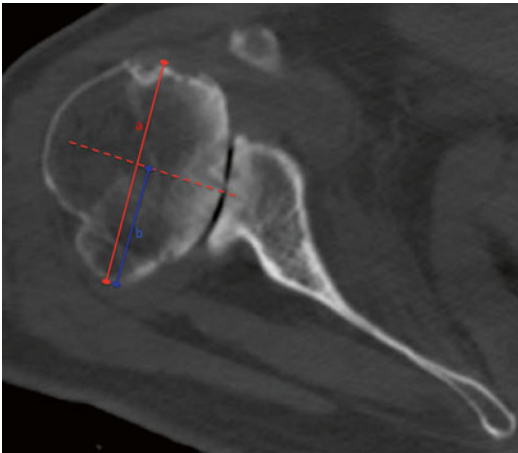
Subluxation* – subluxation of the humeral head can be appreciated best on axial CT images. Using the midpoint of the glenoid axis (line between the anterior and posterior limits of the glenoid), the distance between this center point and the posterior limit of the humeral head (line *b*) is divided by the distance between the anterior and posterior limits of the humeral head (line *a*). The glenohumeral relationship can then be classified as centered (35–65%), posteriorly subluxated (>65%), or anteriorly subluxated (<35%)
